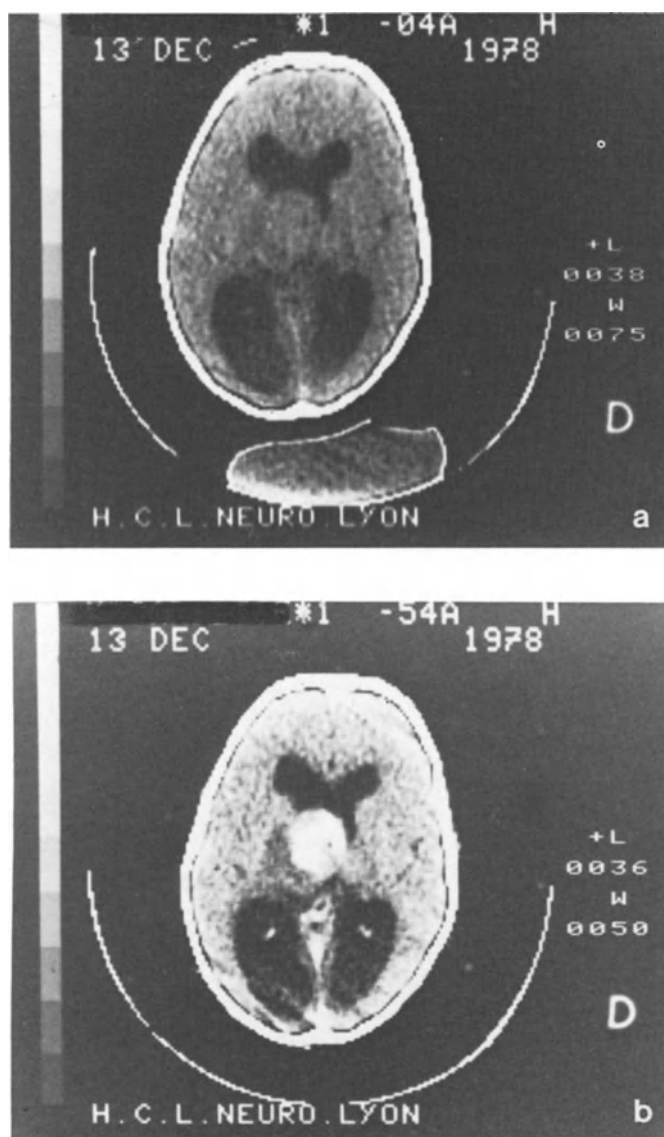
Spongioblastic astrocytoma. a) Pre-contrast CT: isodense mass. b) Post-contrast CT: massive enhancement
